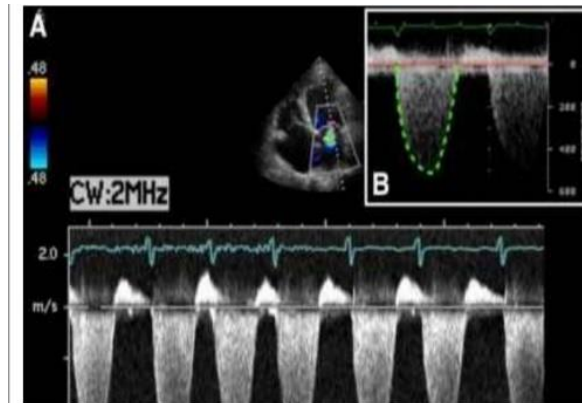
PULSE WAVE DOPPLER IN MR
